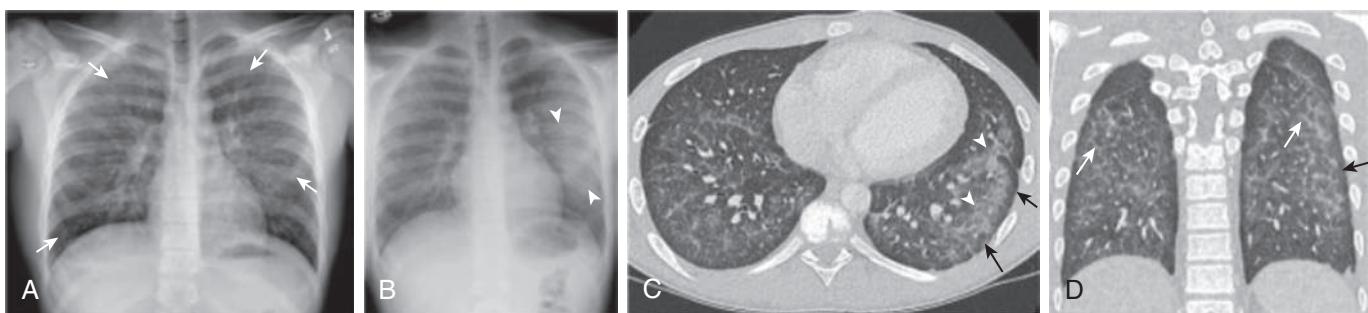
E-cigarette, or vaping, product use–associated lung injury in a 16-yr-old male who presented with chest pain, shortness of breath, and cough for 1 month. A, Posteroanterior (PA) radiograph of the chest demonstrates faint nodular opacities in both lungs (arrows) with diffusely increased interstitial markings. B, PA radiograph of the chest obtained 2 days later demonstrates progression of the nodular opacities into confluent opacities in the left mid-lung (arrowheads). Axial (C) and coronal (D) chest CT images in lung windows (slice thickness 0.63 mm, kVp 100, mAs 61–106) obtained 4 days after the initial chest radiograph demonstrate centrilobular ground-glass nodules in both lungs and confluent ground-glass opacities in the left lower lobe (arrowheads) with subpleural sparing (black arrows) and interstitial septal thickening (white arrows). (From Thakrar PD, Boyd KP, Swanson CP, et al. E-cigarette, or vaping, product use–associated lung injury in adolescents: a review of imaging features. *Pediatr Radiol*. 2020;50:338–344, Fig. 1, p. 340.)
